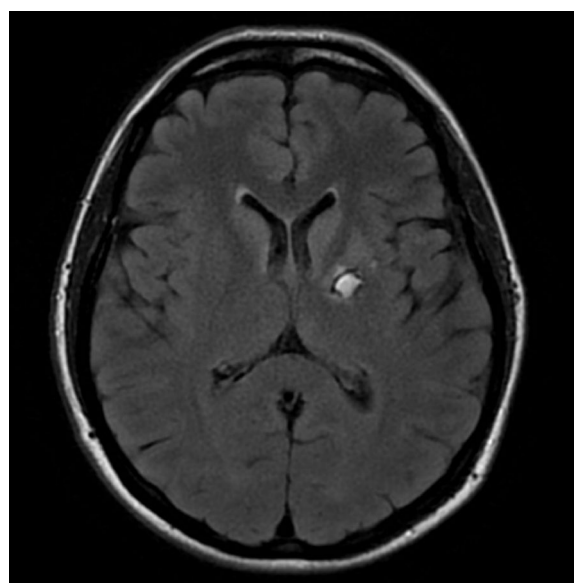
Brain magnetic resonance imaging revealing subacute hemorrhage involving the left basal ganglia
